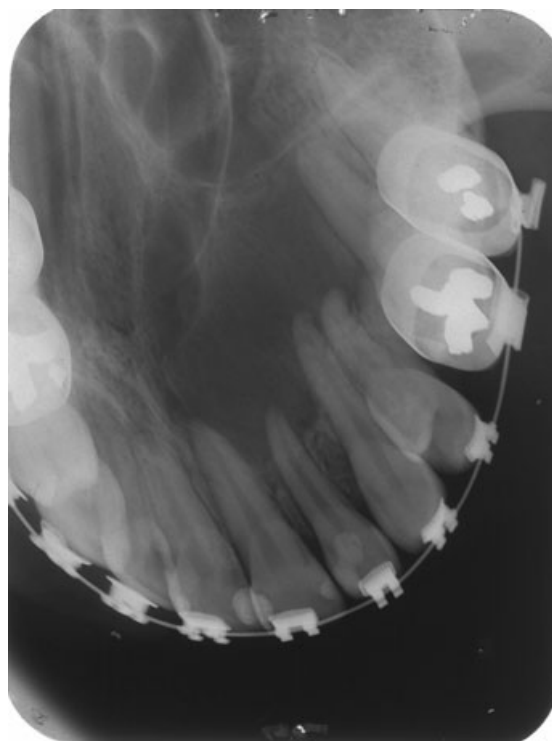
Occlusal radiograph showing bony radiolucency involving two-thirds of the left maxilla.
